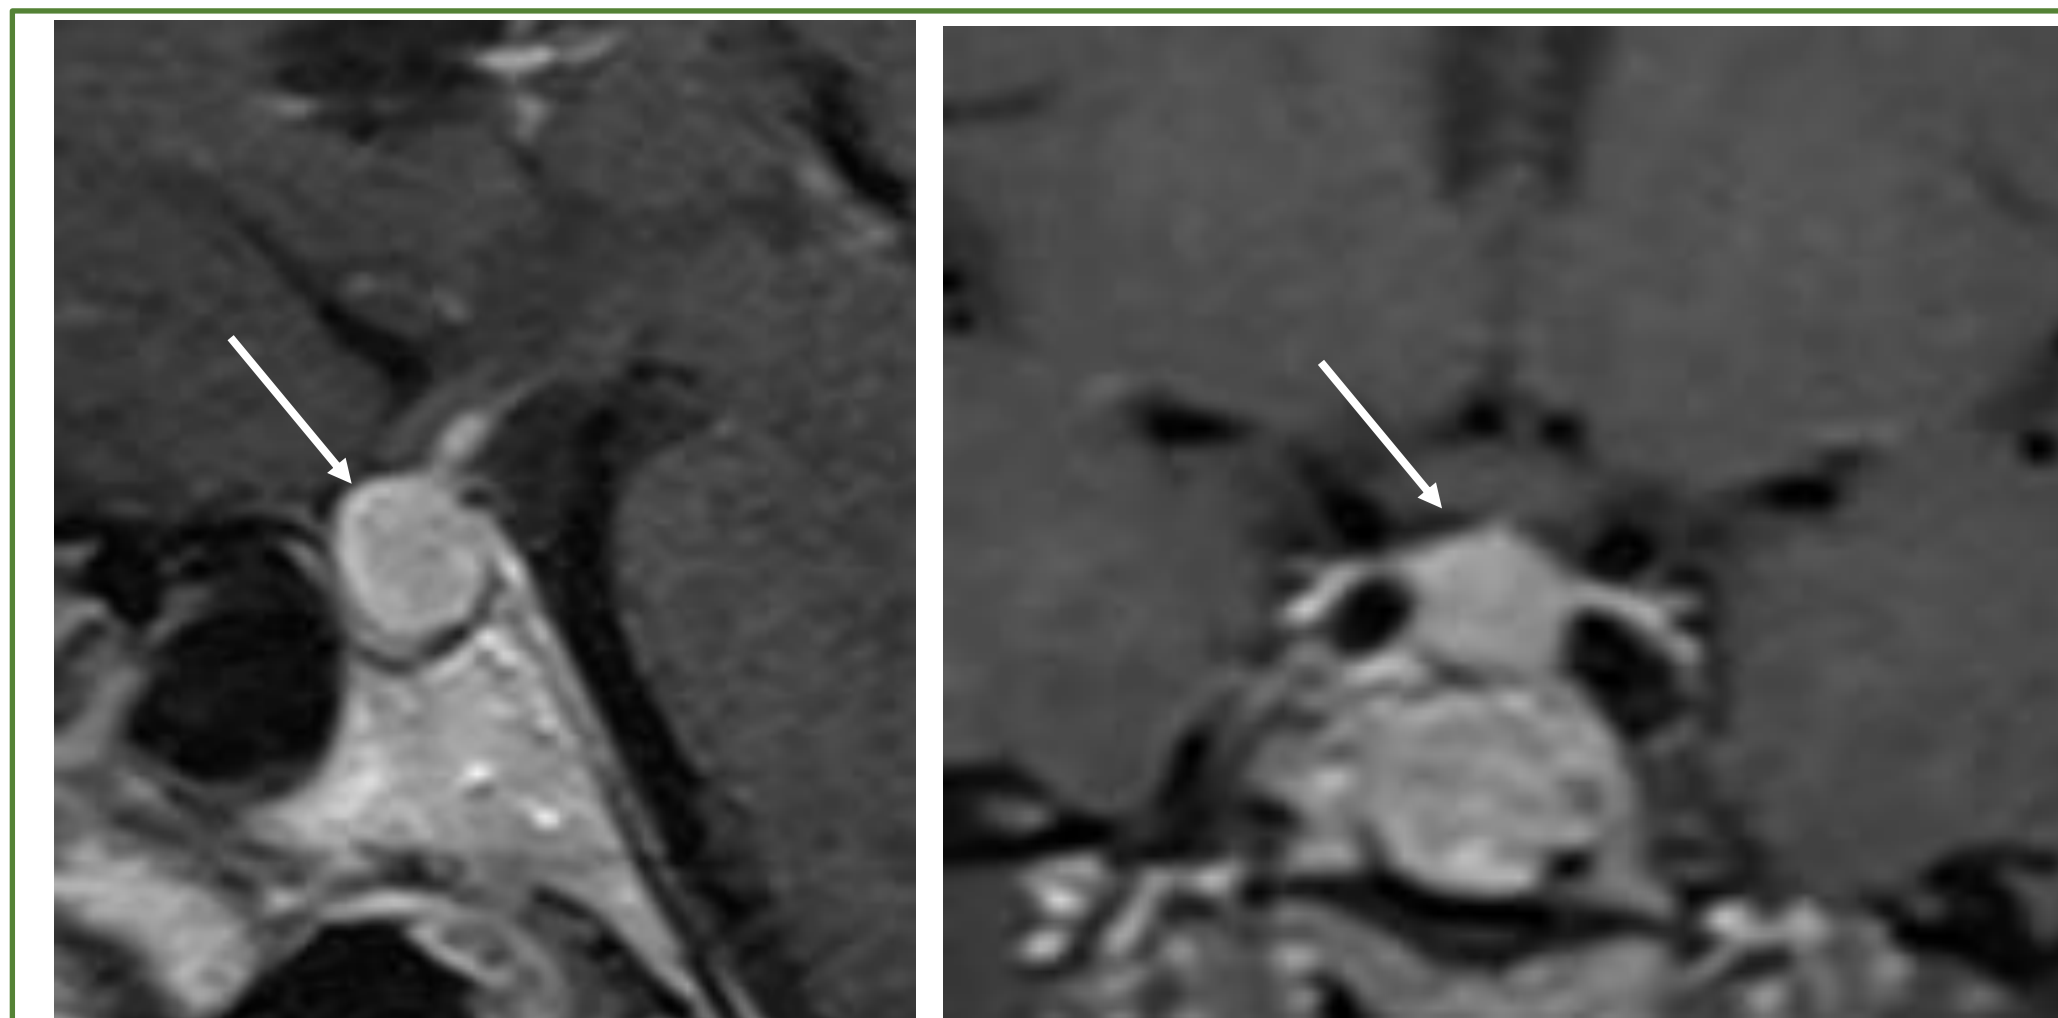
Imaging after 7 months of CAB on contrast enhanced MRI
